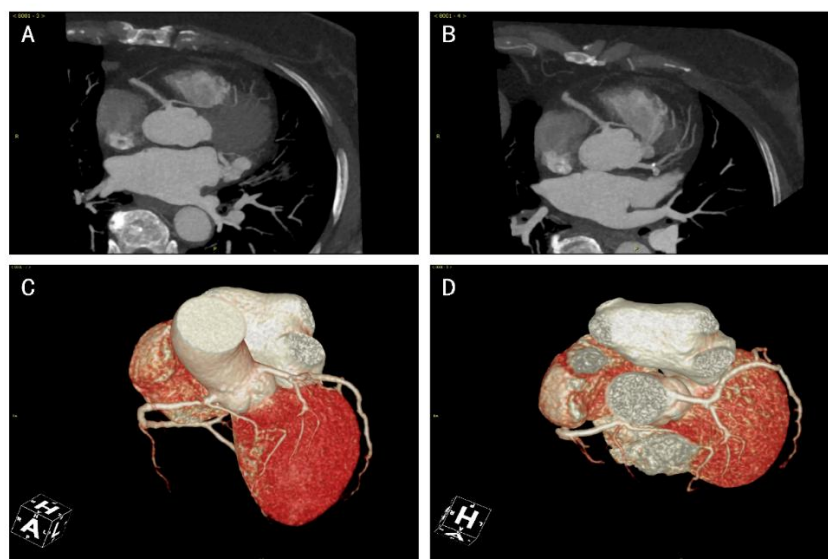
Results of coronary artery CT angiography (CTA)
